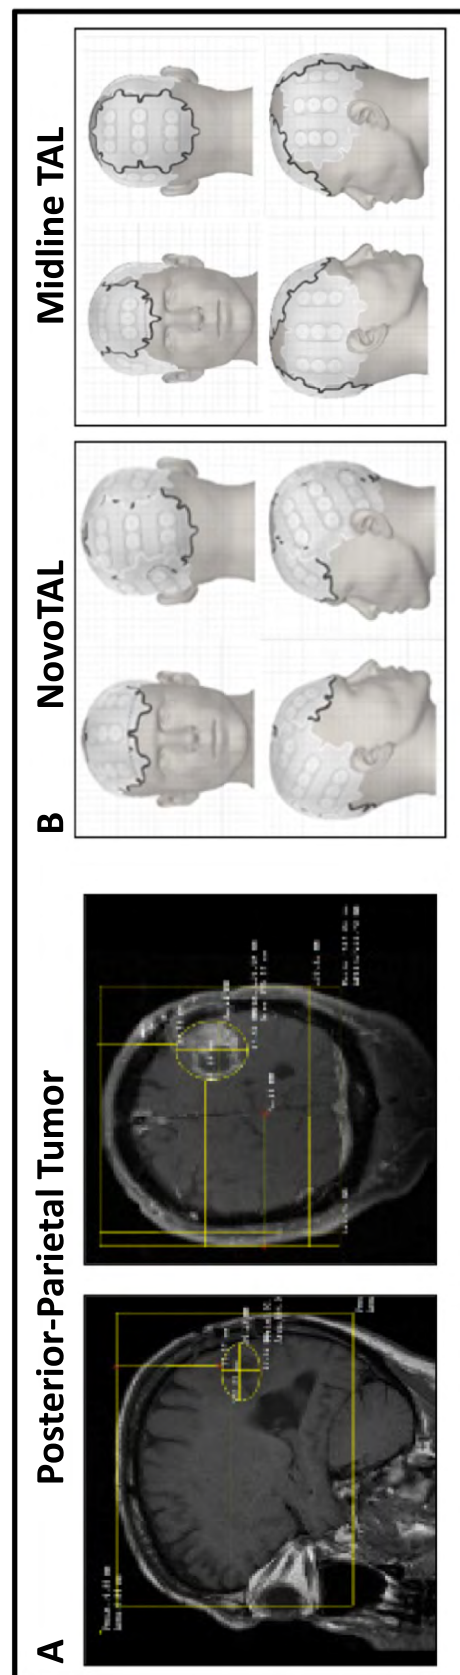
NovoTAL treatment planning. (A) Representative NovoTAL treatment planning performed on MRI sagittal and axial T1 post-contrast sequences of a posterior-parietal tumor. (B) Corresponding array layout generated using the NovoTAL System (left) and symmetric midline array configuration for the same tumor (right).<sup>24</sup>
